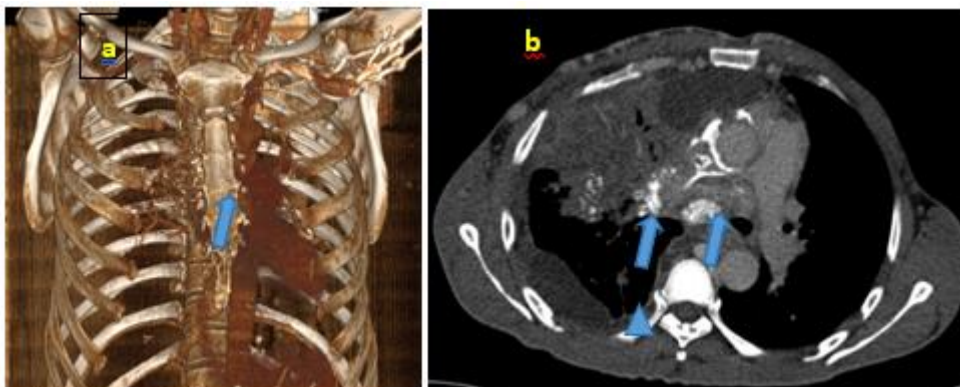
Contrast-enhanced thoracic CT (coronal) showing a complete thrombosis of the superior vena cava (a), extending into the left brachiocephalic trunk (b) all with parietal calcifications and minimal enhancement after contrast
